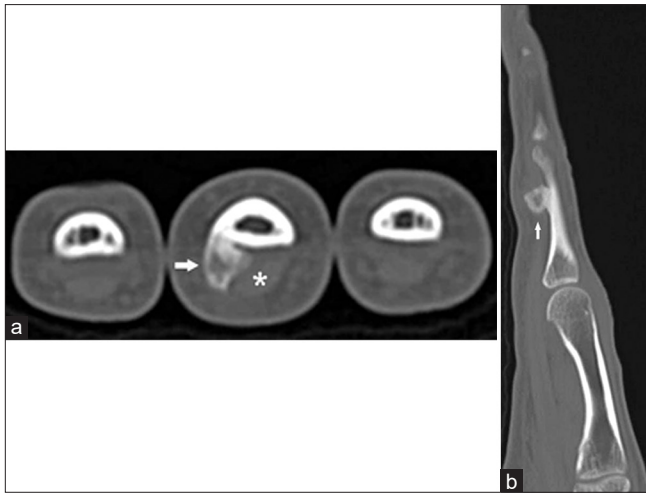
(a) Axial CT image (bone windows) at the level of the proximal second to fourth phalanges shows an ossified mass (arrow) arising from the bone cortex causing displacement of the flexor tendon (asterisk). (b) The sagittal MPR CT image in the bone reconstruction algorithm of the affected middle finger shows the broad-based ossified lesion (arrow) originating from the cortical surface of the bone. Note the sparing of the cancellous bone. CT: Computed tomography, MPR: Multiplanar reconstructed
